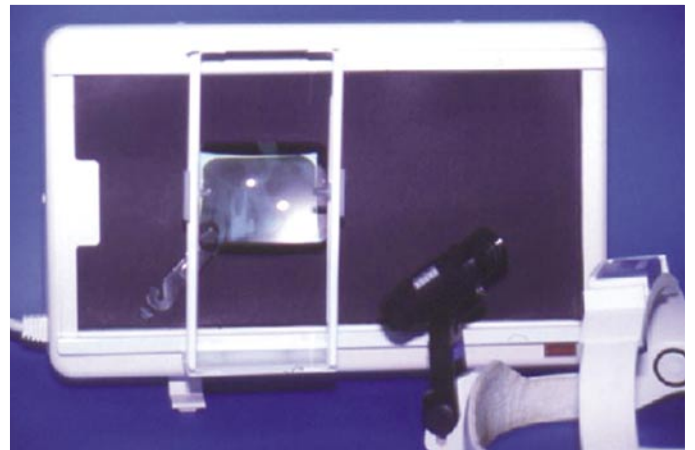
Screened X-ray examination table and optical magnification systems.
